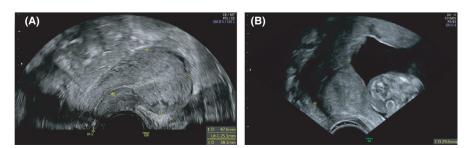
Transvaginal sonographic imaging of the "neo-cervix": (A) Transvaginal imaging after two cesarean sections; (B) Second-trimester cervical length measurement during the fourth pregnancy
